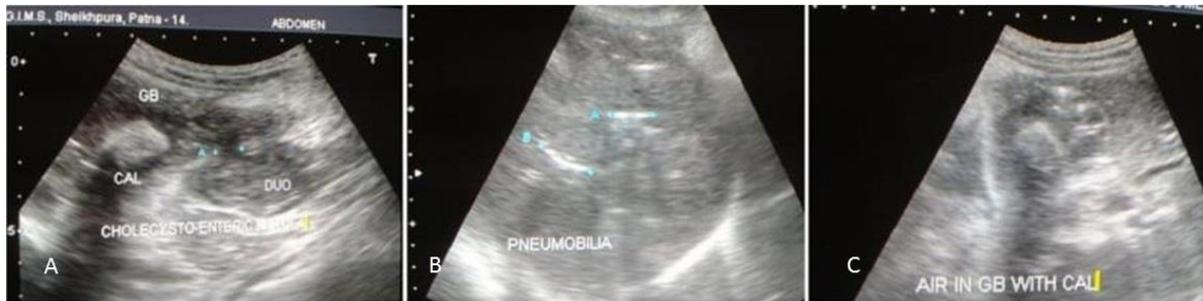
(A) Axial sonogram shows fistula between gallbladder and duodenum and a large calculus within lumen of GB; (B) Longitudinal sonogram of liver shows pneumobilia as cursor shown between A and B; (C) Axial sonogram shows multiple air foci with ring down artefact within lumen of GB along with echogenic structure with acoustic shadowing suggestive of calculus.
